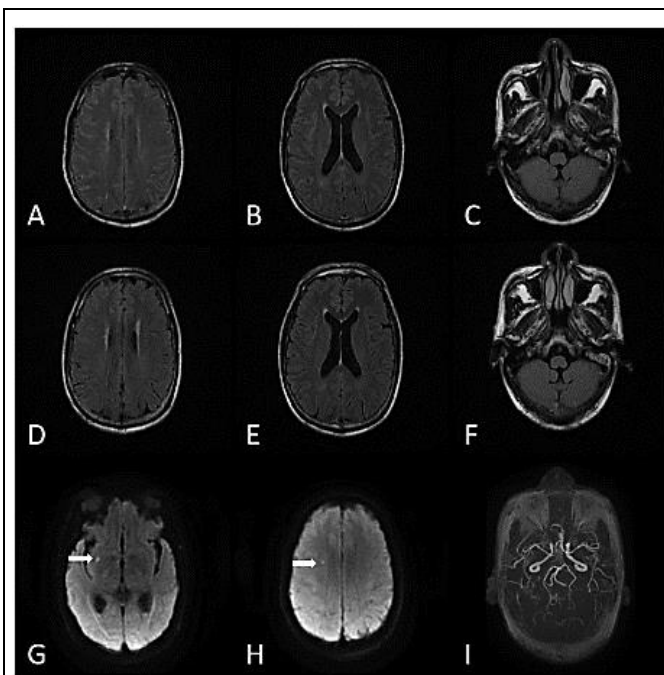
Imageological examination. FLAIR sequence of brain magnetic resonance imaging (before treatment (A, B, C) - after treatment (D, E, F)). DWI sequence and MRA of brain magnetic resonance imaging (G, H and I).
